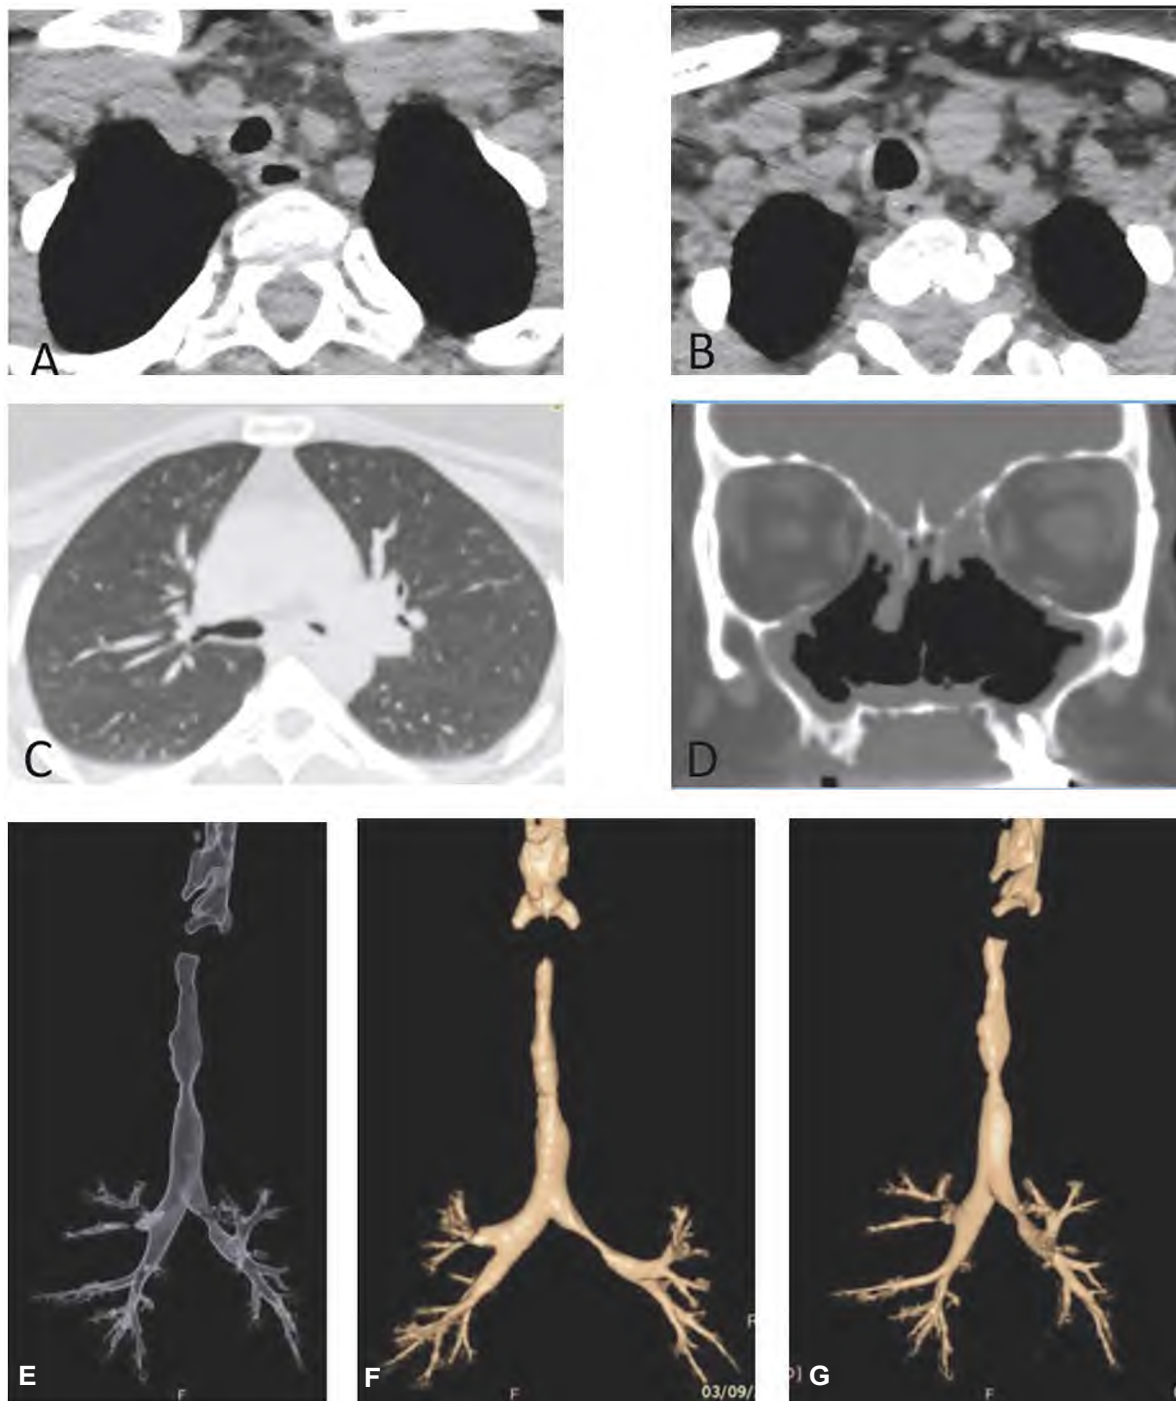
A case of granulomatosis with polyangiitis (A, B) axial CT images of the trachea (B) axial CT image of the lung at the level of main bronchi (D) coronal CT of the paranasal sinuses (E-G) 3D volume rendering of the tracheo-bronchial tree. Images demonstrate tracheal involvement in the form of circumferential mural thickening and stenosis extending from the subglottic airway to the proximal intra-thoracic trachea with another short stenotic segment involving the left main bronchus. Coronal images of the paranasal sinuses show destructive changes of the nasal septum, nasal turbinates and medial walls of both maxillary antra.
